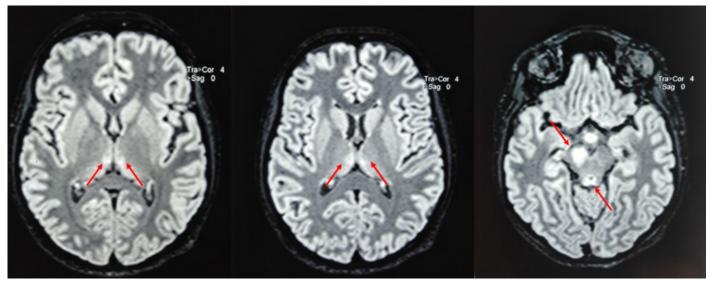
MRI findings. Bilateral and symmetrical hyper intense lesions on T2-weighted and FLAIR sequences in periaqueductal gray matter, thalamus, and mammillary bodies (arrows)
